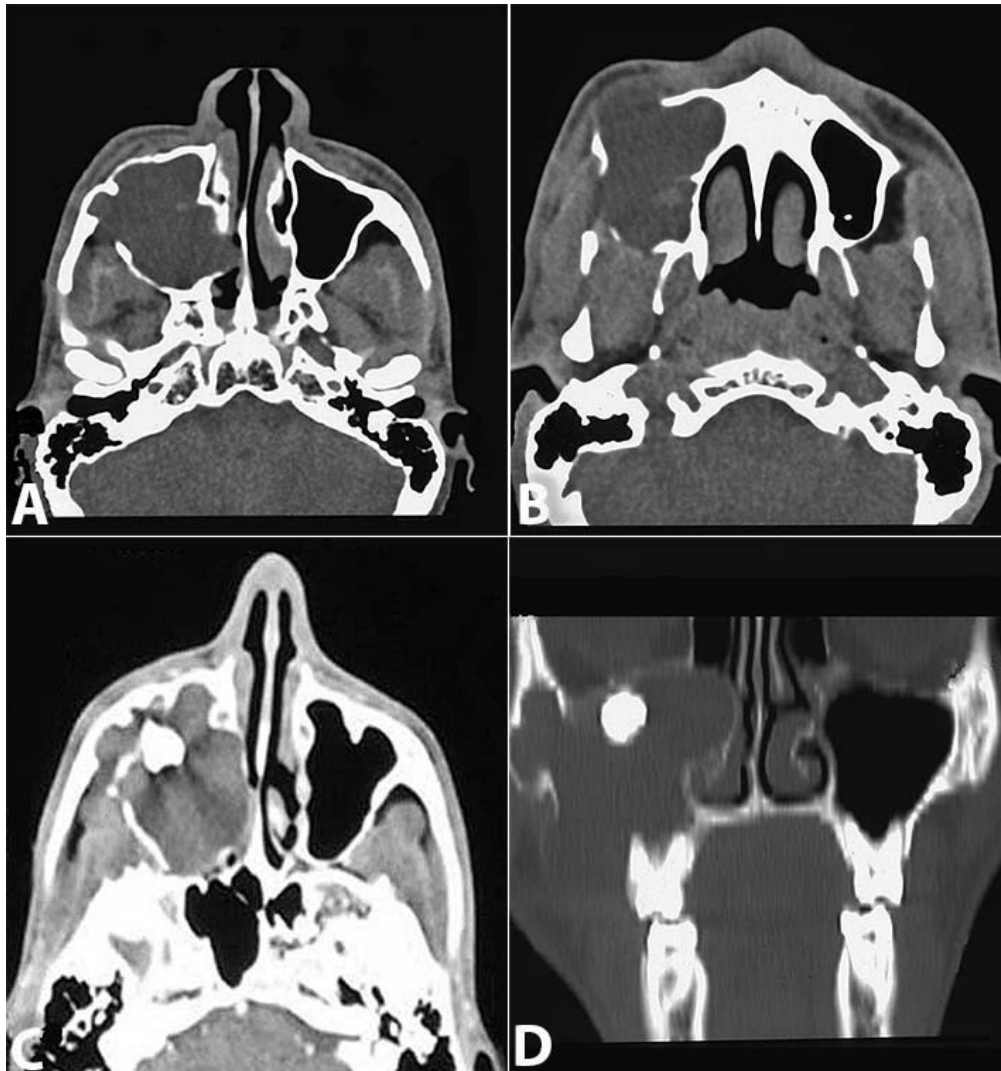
Axial CT of the sinuses. A - Complete opacification of the right antrum; B - Thinning and irregular destruction of the antral walls is evident; C - Displacement of right maxillary third molar; D - Coronal view showing the extensive lesion involving the right antrum and infiltrating into the right nasal cavity.
